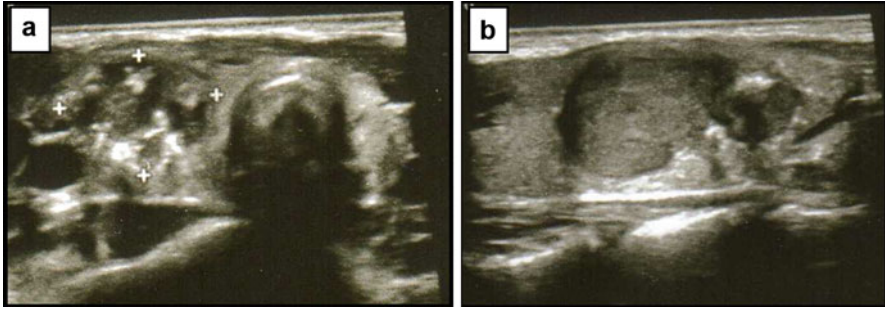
Neck ultrasound imaging of a medullary thyroid cancer (MTC): cross (panel a) and longitudinal (panel b) sections of an intrathyroidal MTC. The ultrasound characteristics are clearly and highly suspicious for malignancy, but no specific features for MTC do exist to induce a specific presurgical suspicion
